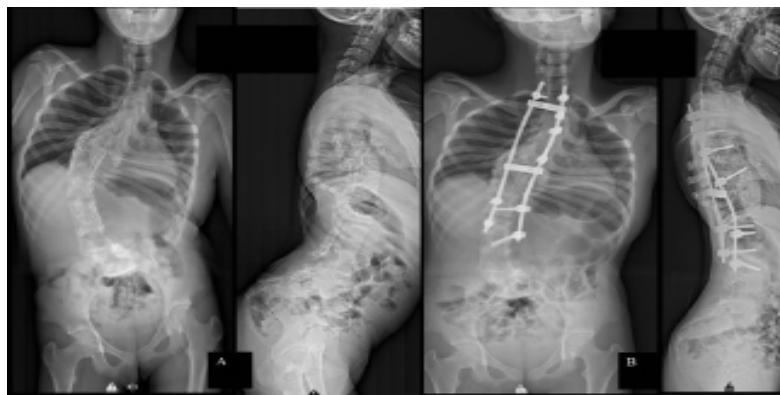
(A) Whole spine radiograph showing thoracolumbar curve with Cobb's angle of 80°, apex at T11 and failure of vertebral segmentation at multiple levels. (B) Improvement in Cobb's angle of 56° with improvement in lung volume post-surgery.
